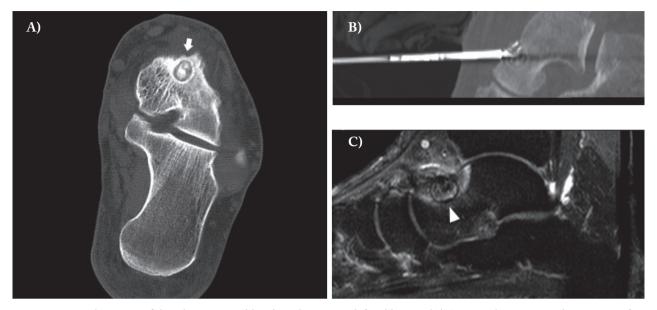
Osteoid osteoma of the talus. 39 year old male with recurrent left ankle pain. (A) CT scan demonstrates the presence of an osteoid osteoma of the talus (arrow). (B) Multiplanar reconstructions are used to guide the electrode inside the lesion. (C) 30 days post-treatment MRI showing regular thermal ablation outcomes (arrowhead)
